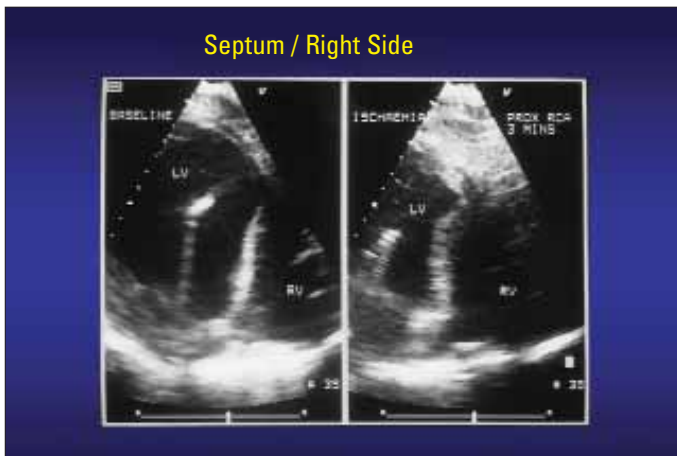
Transesophageal echocardiogram showing bowing or stretch of septum to left side after right coronary artery occlusion with intact pericardium, as shown by Brooks (42). Similar displacement occurs with septum paradox following cardiac surgery. (Reproduced from reference 42 with permission of LWW. Copyright 1999.)
